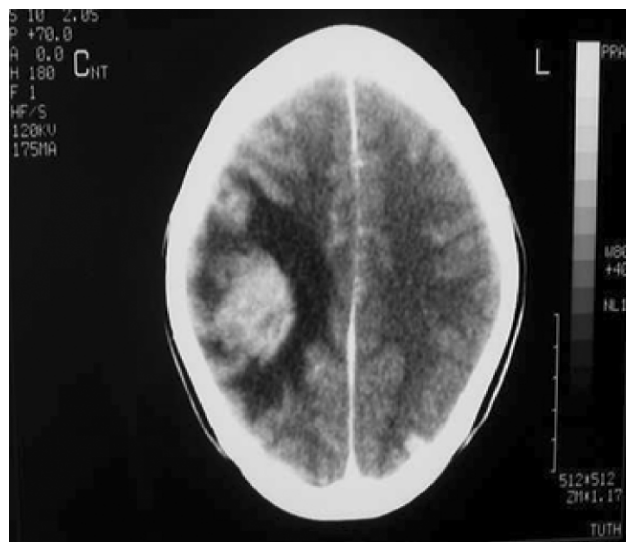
3 B. Plain and contrast enhanced CT scan of head shows haemorrhagic lesion in the right parietal region with perilesional oedema.
